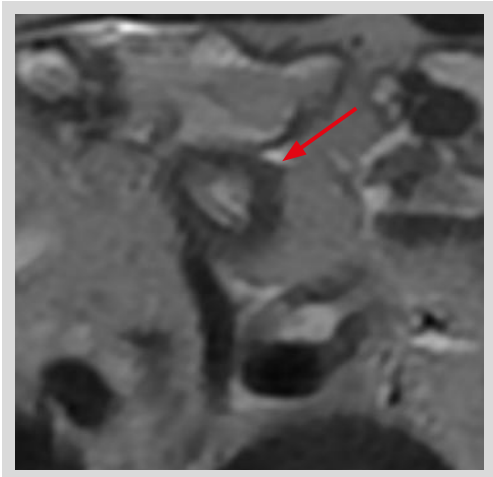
19 year old man, abdominal pain and emesis, CT and Colonoscopy of ileitis, Diagnosis: Stenosing ileal CD. EnteroMR mixed disease of the distal ileum with signs of activity and chronic fibrostenotic changes MARIAs: 3. T2 SEQUENCE: Parietal thickening, T2 signal hyperintensity due to submucosal edema, inflammatory changes of the mesenteric fat as signs of activity.
